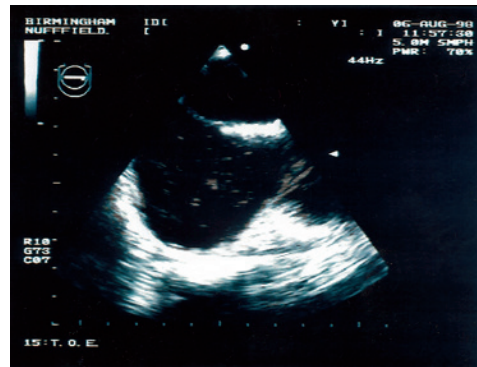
Trans-oesophageal echocardiograph showing reduced fat embolization following a BIRMINGHAM HIP® Resurfacing.
